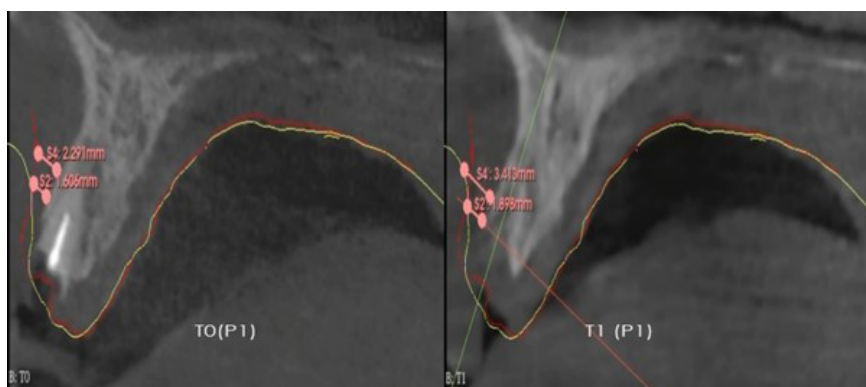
Visualizing 3D Superimposition and Alignment of Two DICOMs on Preoperative Cone Beam CT scan: Soft Tissue Boundary Representation. The red line represents the preoperative soft tissue limits while the yellow line represents the postoperative soft tissue limits.
